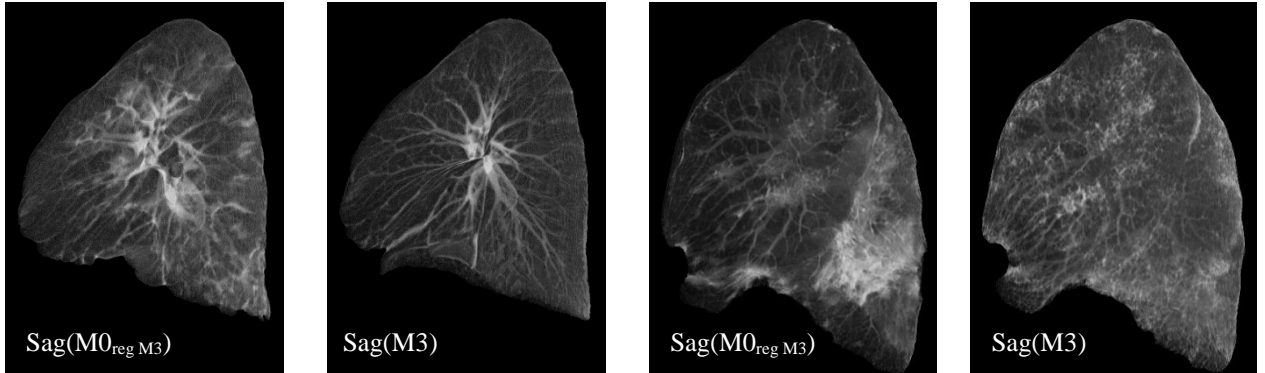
CT attenuation change between M0 (registered to M3) and M3, estimated on sagittal projections (here left lung shown). (a) state improvement (ground glass regions disappear at M3) (b) worsening (persistence/extension of fibrotic regions at M3)
